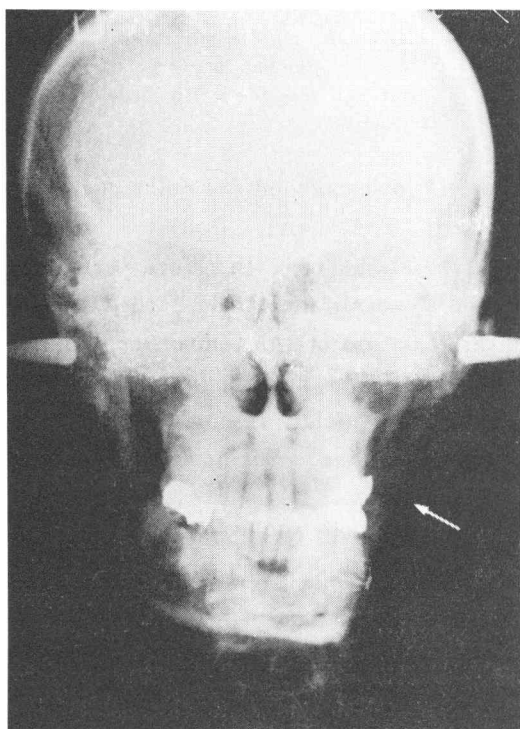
Postanterior radiograph the second year after iliac bone regrafting (arrow) of Case 3.
